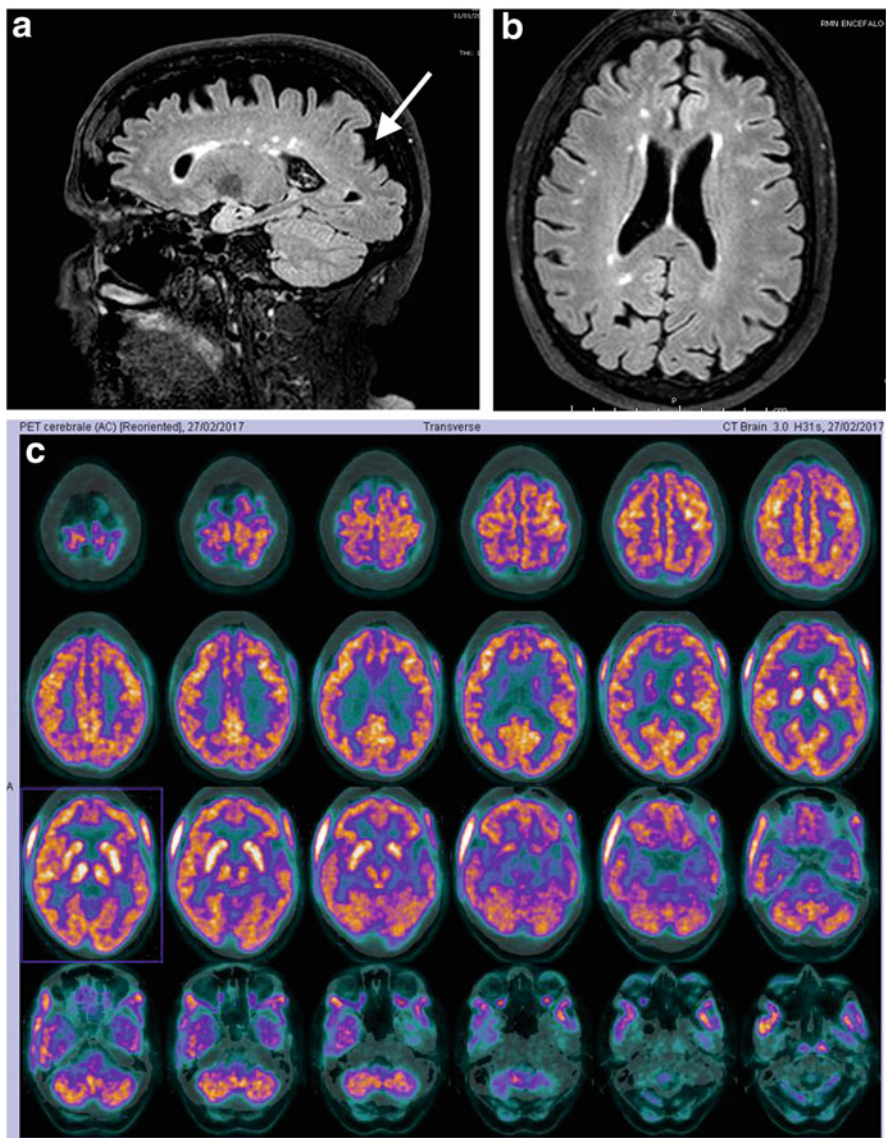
(Panel a) T1-weighted sagittal image shows a moderate enlargement of the sylvian fissures. (Panel b) T1-weighted axial image shows white matter hyperintensities, probably on vascular bases most expressed in the periventricular white matter. (Panel c) FDG-PET shows areas of modest reduction of the fixation of the analogue of radiolabeled glucose at the mesial regions of the temporal lobes of both sides, predominantly in the left one
